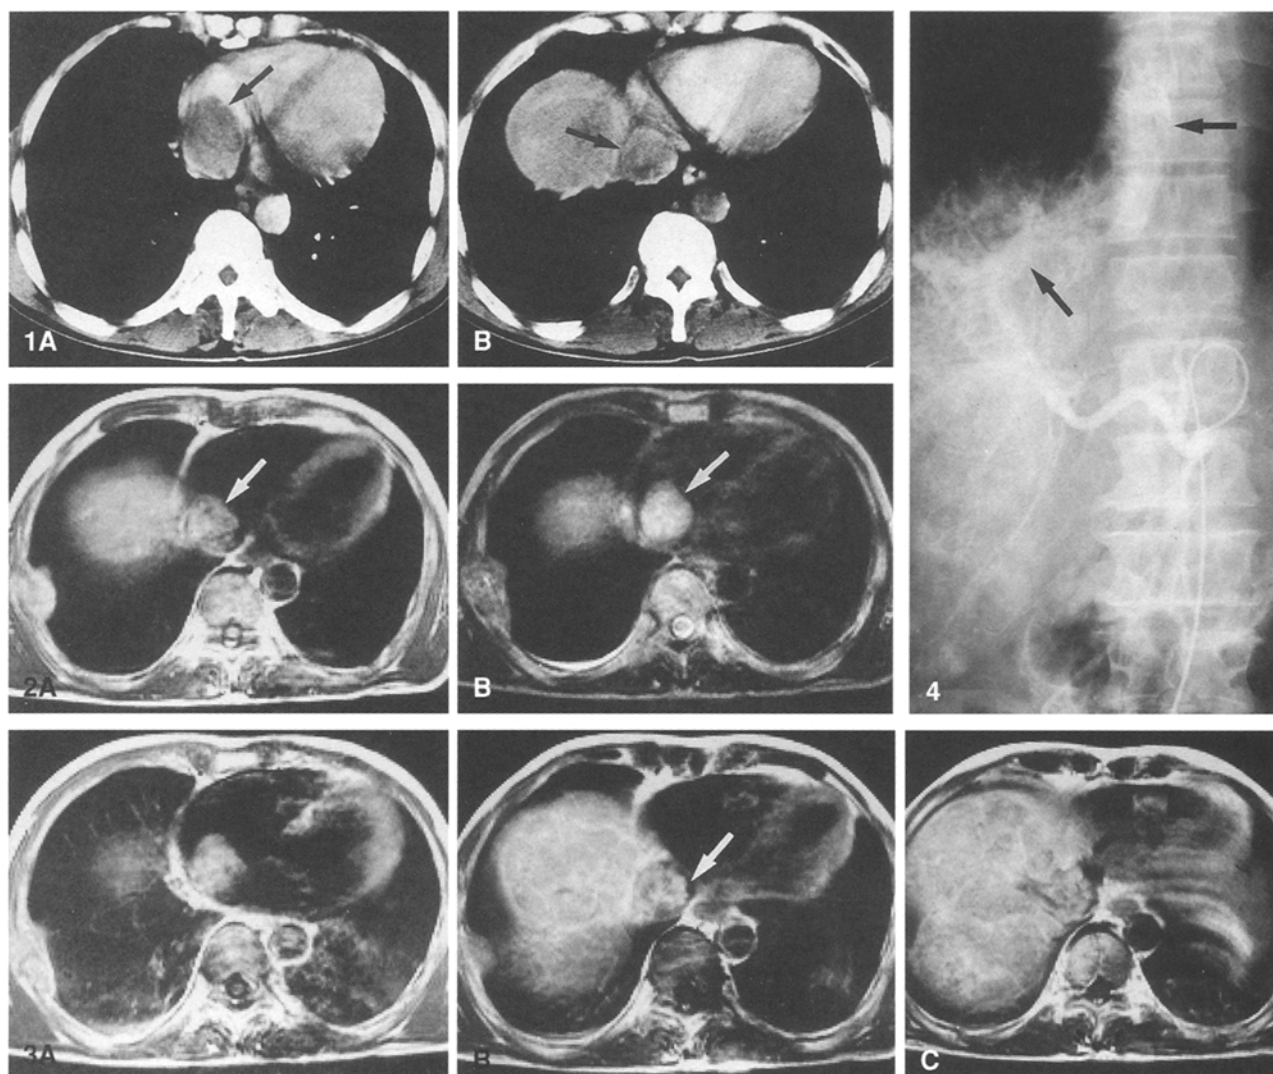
Enhanced CT scan shows 3 × 4 and 3 × 3 cm low-attenuated TT in the RA (A) and IVC (B), respectively (arrows).
